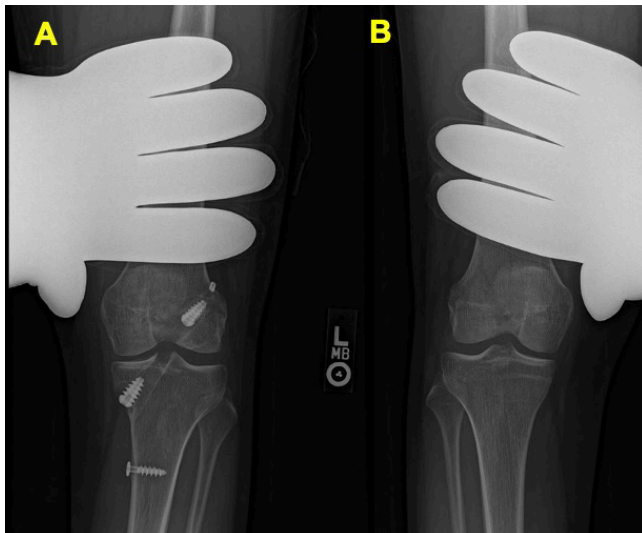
(A) Left knee varus stress radiograph from a revision ACLR patient case. (B) Healthy right knee varus stress radiograph from the revision ACLR patient case, which was used to compare to the post-operative knee. Stress radiographs can be used during initial patient evaluation to determine if concomitant posterolateral and medial knee injuries are present. They can also be used post-operatively in combination revision ACLR and fibular collateral ligament reconstruction cases to confirm that pre-operative gapping has been eliminated and that the revision ACL graft is stable.
